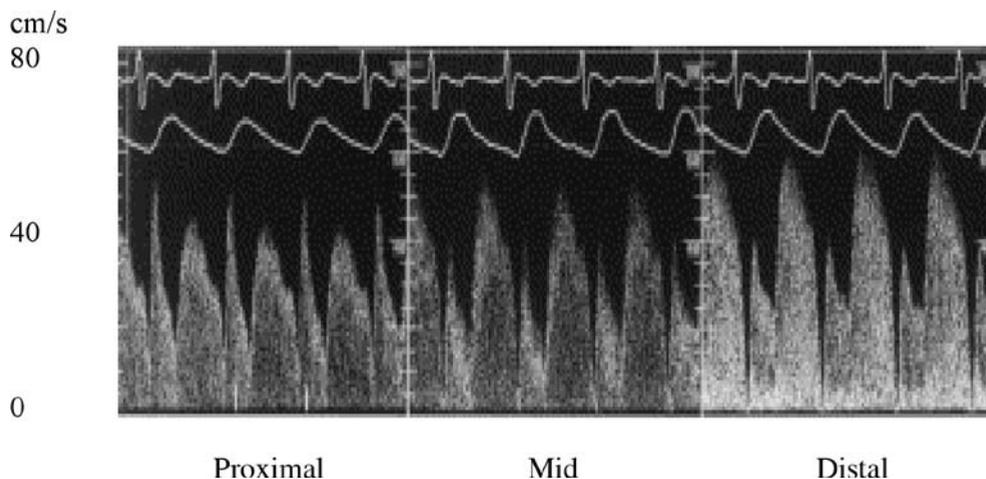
Ultrasound baseline flow recordings in a patent LIMA to the LAD graft.
